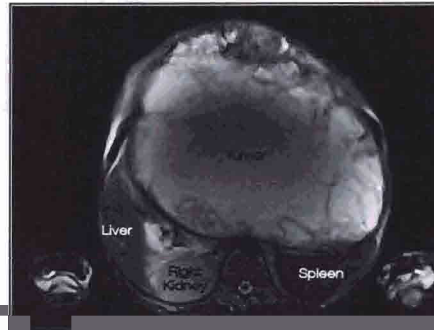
MRI revealed large tumor which displaced all internal organ.
